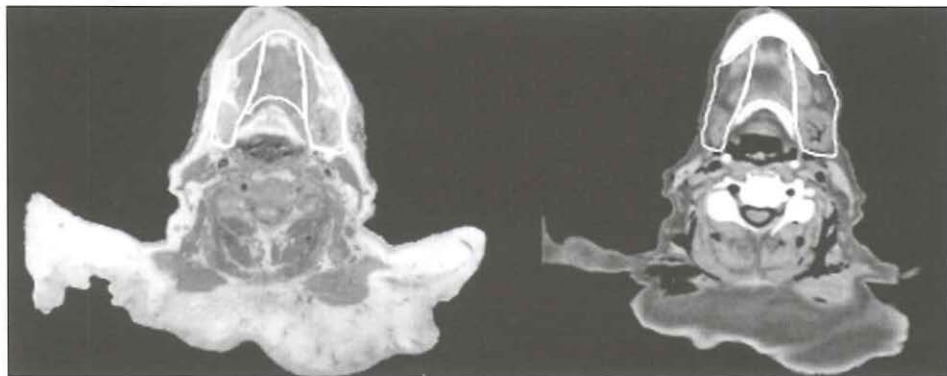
Region 1: this region is divided into Subregions 1A (submental lymph nodes) and 1B (submandibular lymph nodes). The borders are outlined on a transversal anatomy slice (left panel, see text) and the matched CT slice (right panel). The slices are at the upper border of Region 1A (see text). The borders are discussed in the text and in Table 1.
